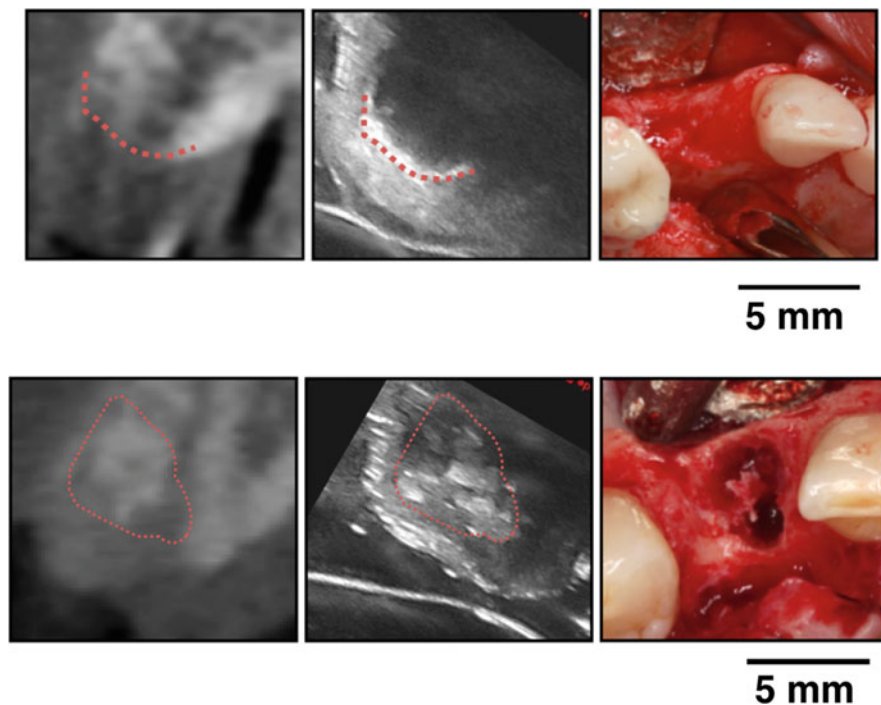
Top: Normal healing with enclosure of the crestal cortical plate. A bright (hyperechoic) line (red dotted line) is shown on the ultrasound (US) image, indicative of intact bone surface. The image is consistent with the CBCT image and clinical photo. Bottom: Impaired healing with soft tissue invagination, encircled by the red dotted line, in the bone and failure of crestal cortical bone formation on the US and CBCT images. The clinical photo confirms this finding after removal of the soft, non-integrated soft tissues and bone particles
